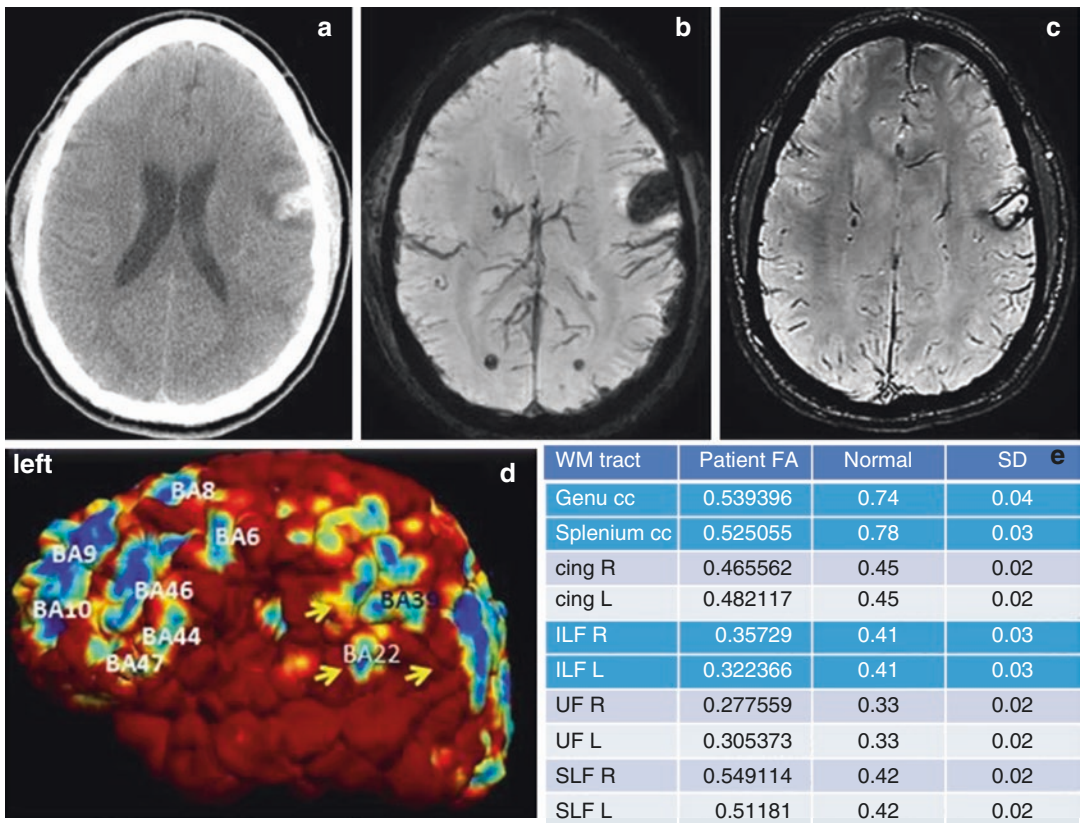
Patient is a 20-year-old male admitted to the hospital for 30 ft. fall from oil rig. Patient was helicoptered in from the field and intubated due to low GCS 4–5. Presented with subarachnoid hemorrhage, brain laceration in the left frontal lobe, multiple skull fractures. *After 3 years the patient showed cognitive decline, depression, bursts of anger, decreased capacity for planning, bad social interaction.* Never returned to work. (a) Computed tomography in transverse view showing laceration and hematoma in left
